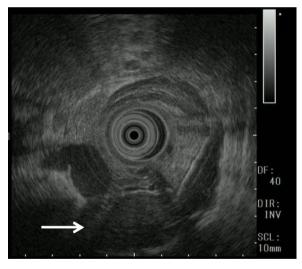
Endoscopic ultrasound showed a 30×20 -mm submucosal tumor of the duodenal bulb.
